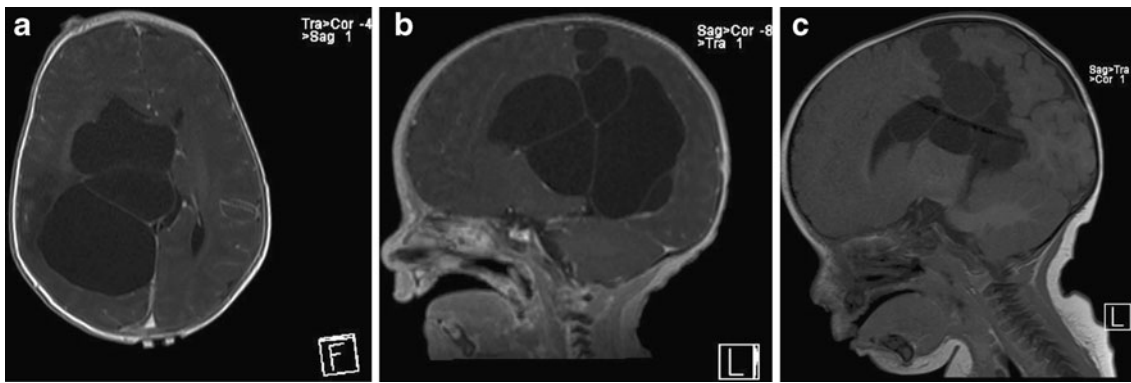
a–c Pre- and post-operative magnetic resonance images of case 3, demonstrating a loculated arachnoid cyst and subsequent reduction in cyst size after fenestration and shunt placement. a Pre-operative
